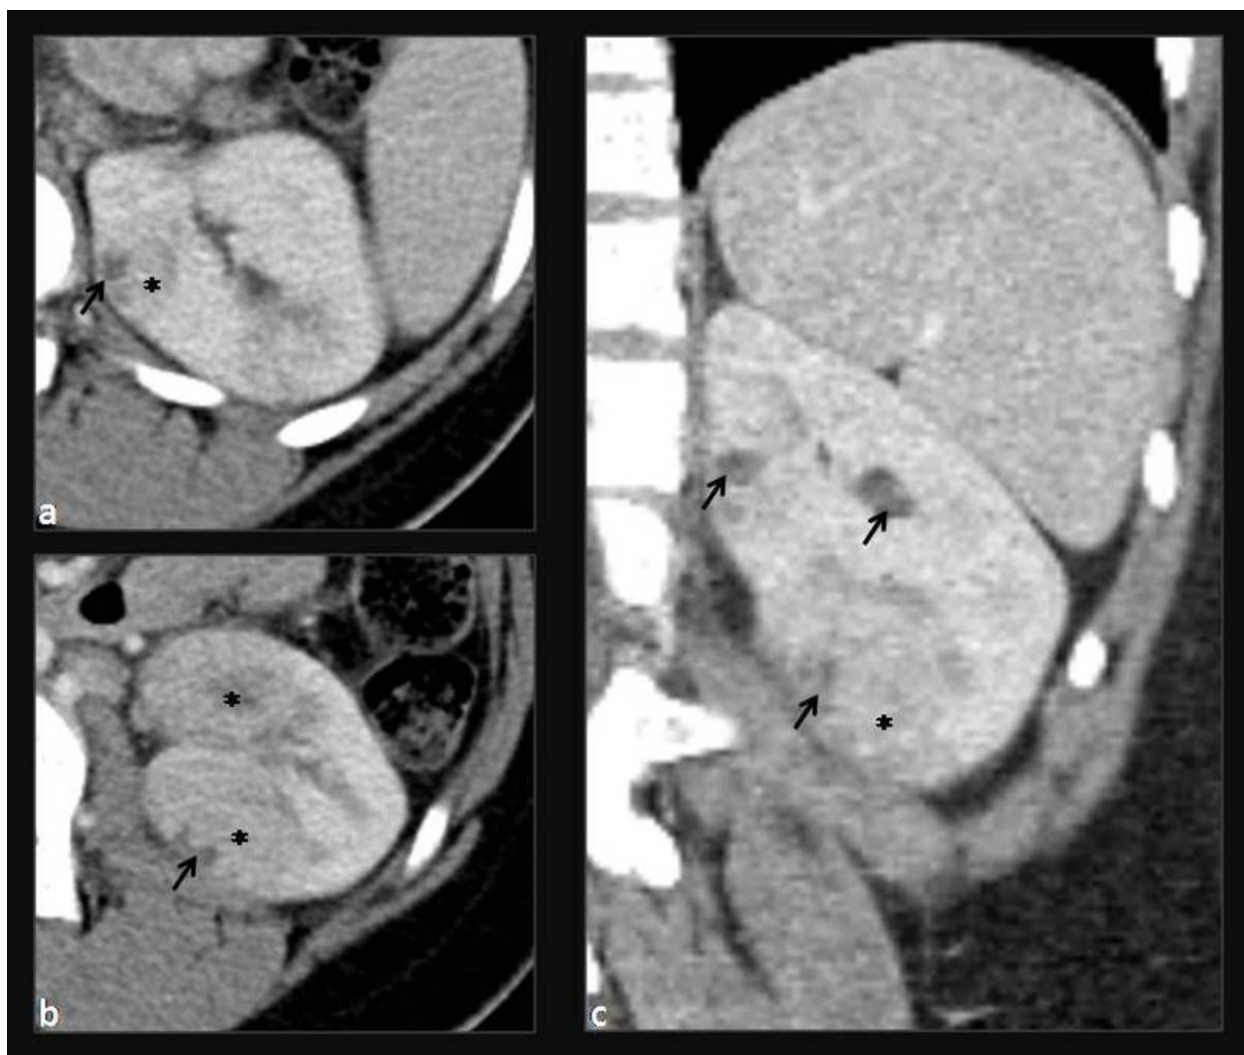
Acute pyelonephritis with microabscesses. Axial (a and b) and coronal (c) contrast-enhanced CT images show several wedged-shape areas of decreased enhancement (*) and small collections representing microabscesses (arrows) which were not seen on ultrasound scan.
